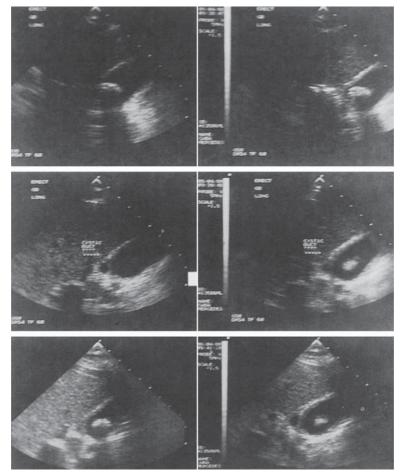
Ultrasound, a nonionizing source, viewing the gallbladder, with no harmful biologic effects. Large dense white objects noted in each field represent gallstones.
